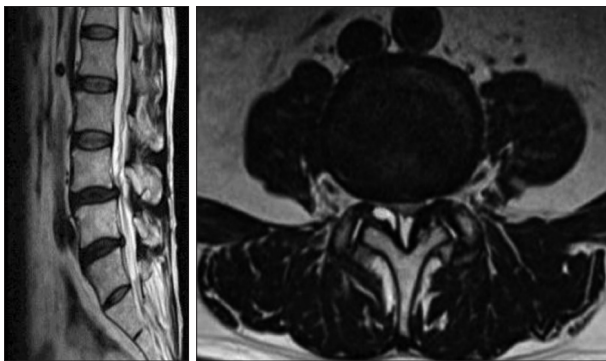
T2-weighted magnetic resonance images taken after 4 years show the presence of a cyst on the right L3–4 facet joint. The previous left facet cyst is absent.
